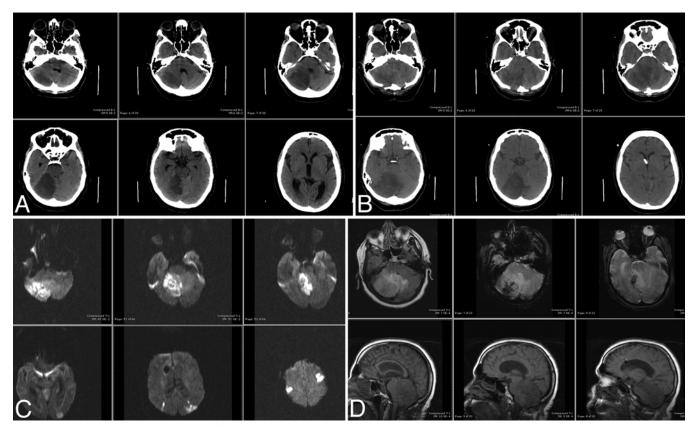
Images obtained in a 56-year-old woman with mitral regurgitation, who underwent cardiac surgery and developed decreased consciousness 1 day later. A: Axial CT scans of the brain without contrast demonstrate a large infarction of the right cerebellar hemisphere with mass effect and hydrocephalus. B: Due to progressive obtundation, the patient underwent suboccipital craniotomy and partial removal of infarcted tissue. The bone flap was replaced and left floating. These postoperative axial CT scans reveal persistent mass effect. C: Postoperative diffusion-weighted axial MR images demonstrate persistent, widespread infarcted tissue and mass effect. D: Magnetic resonance imaging performed on postoperative Day 3. Axial FLAIR sequence (upper left) shows persistent edema and mass effect. Axial gradient echo sequence (upper center and right) shows hemorrhagic transformation. Sagittal T1-weighted images (lower row) show ascending transtentorial herniation and tonsillar herniation through the foramen magnum. The patient remained symptomatic for the next 2 weeks, suggesting that the bone decompression and/or removal of infarcted tissue was insufficient.
